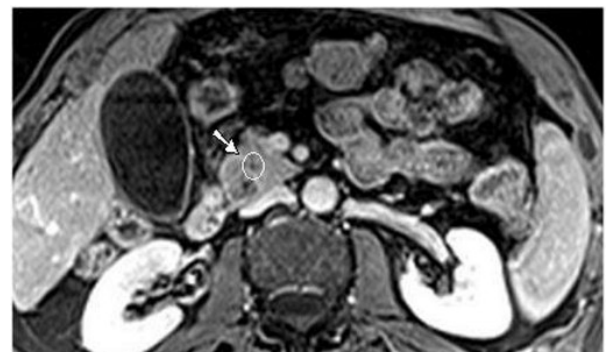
T1-weighted fast-field echo short-time inversion recovery (FFE STIR) post-contrast image shows a solid lesion with inhomogeneous late-phase enhancement (at the level of the intra-pancreatic biliary tract); moreover, MRI demonstrates mild enlargement diffusely involving the head of the pancreas associated with inhomogeneous signal intensity of the pancreatic tissue due to the presence of a hypointense nodule (arrow).
